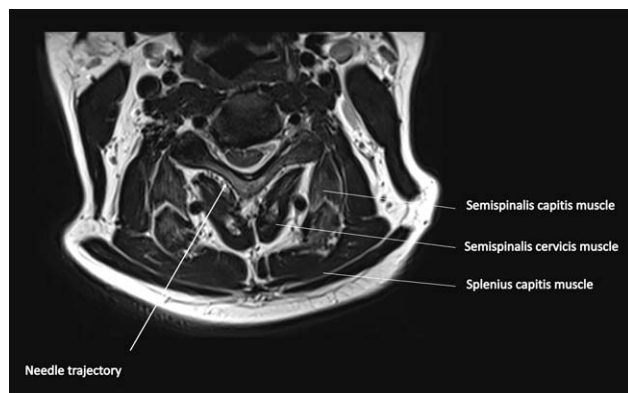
T2 magnetic resonance imaging axial view of cervical spine at the C6 level presenting the needle trajectory and relevant muscles.
